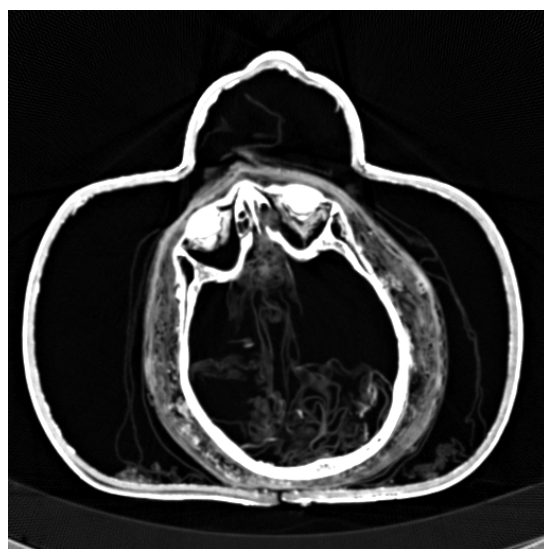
CT through the head showing
